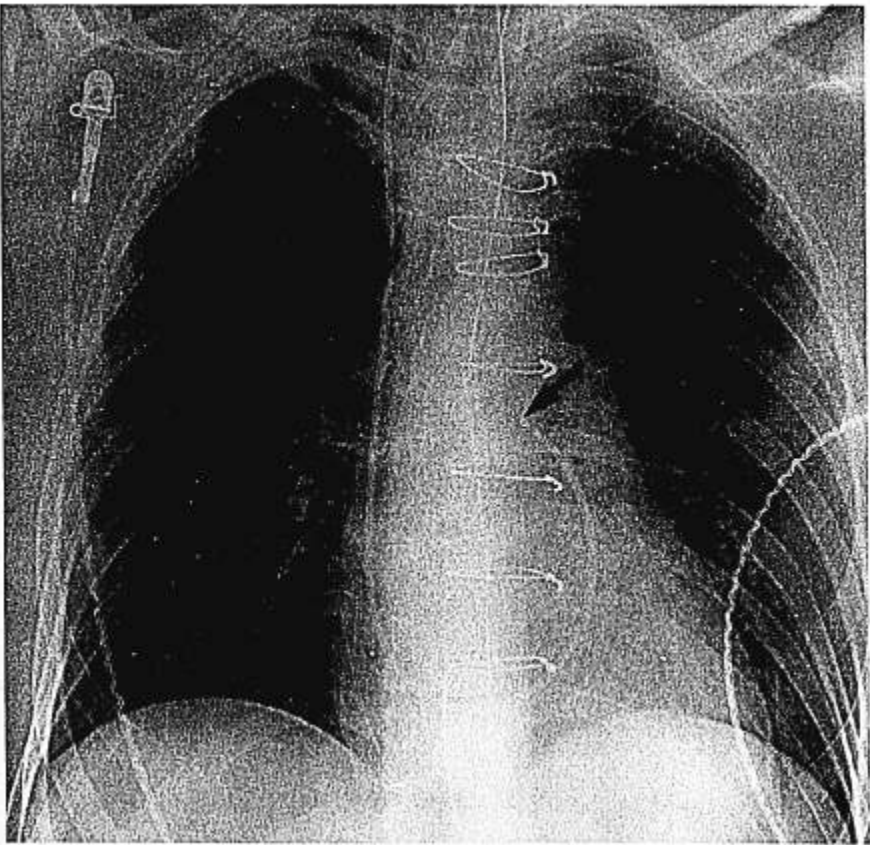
Chest radiograph of a patient with a PA Watch Catheter® showing typical placement of the catheter tip (arrow). In all patients, the catheter tip was located to the left or at the midspinal level of the thoracic vertebrae.
